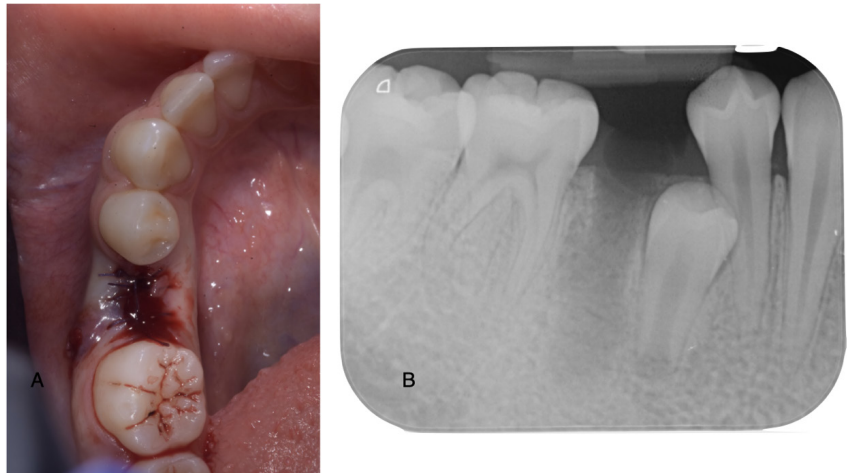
Immediate postoperative photograph (A) and postoperative periapical radiograph confirming the successful surgical extraction of the contralateral premolar (B). Precision and atraumatic techniques were employed to minimize tissue trauma and ensure optimal healing.
